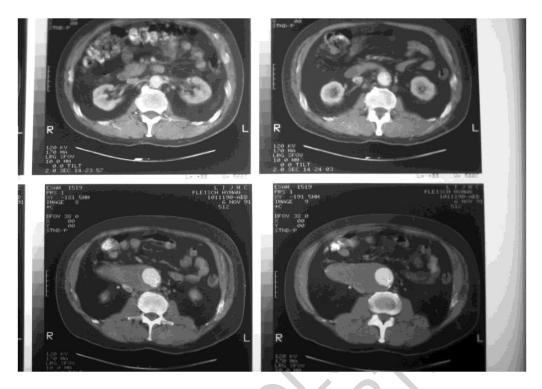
An example of a CT Scan
